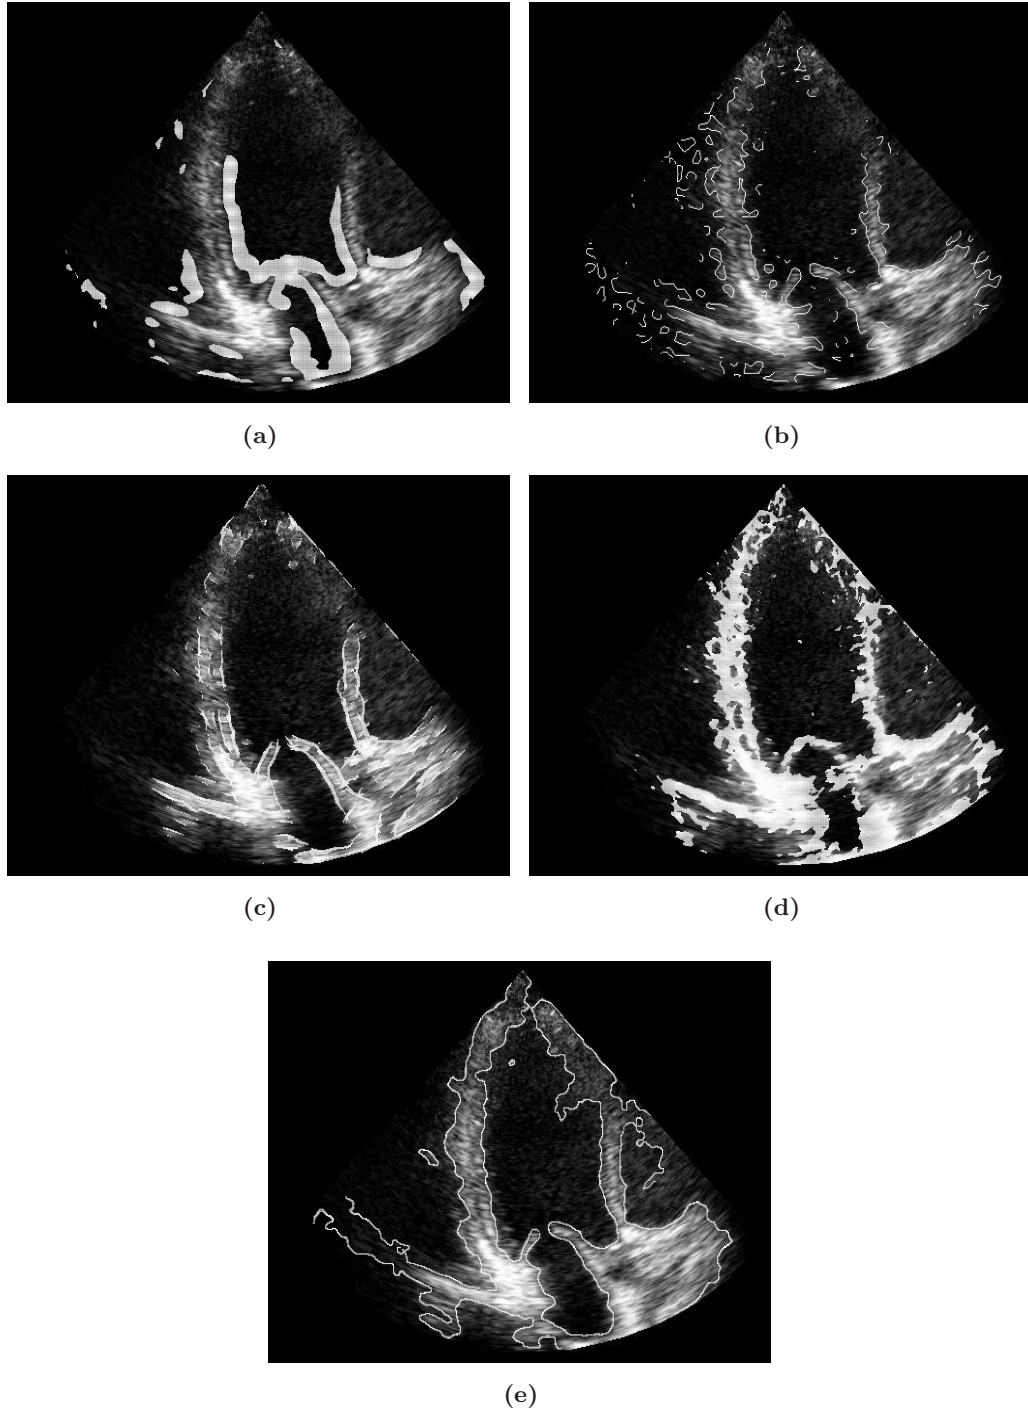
Edge detector output for the clinical ultrasound images of Fig. 6.7(a). (a) CV, (b) RoA, (c) FA, (d) PC, (e) ZC.
